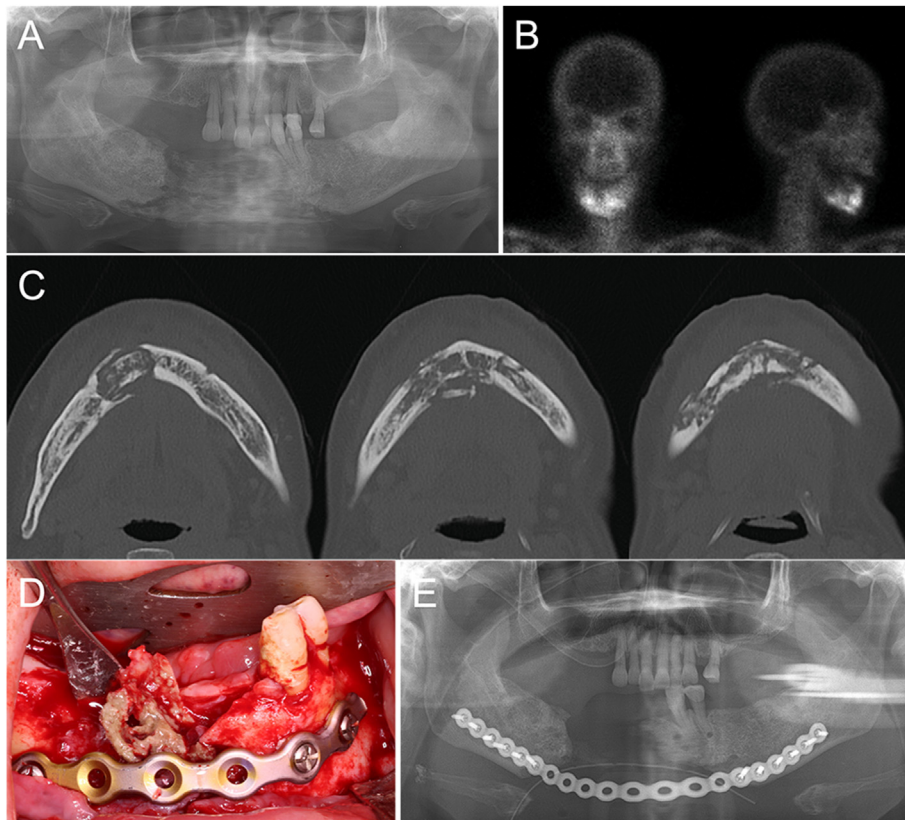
Perioperative radiographs of Case 1. (A) Preoperative panoramic view, (B) bone scan, and (C) computed tomography images showing extensive osteolysis and sequestration with a pathologic fracture. (D) Intraoperative clinical photograph and (E) immediate postoperative panoramic view showing stabilization of the mandibular fracture using a reconstruction plate and conservative surgical treatment.
